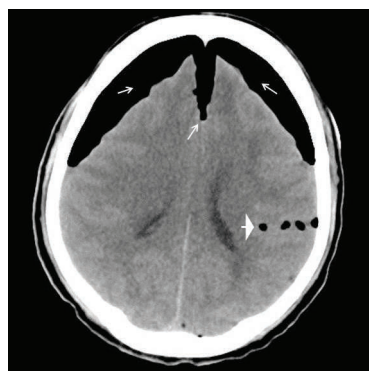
Nonenhanced computed tomography axial sections of brain showing “Mount Fuji sign.” Air noted in bilateral frontal subdural space and interhemispheric fissure (arrows). Also seen “air bubble sign” (arrowhead) in the left sylvian fissure.
